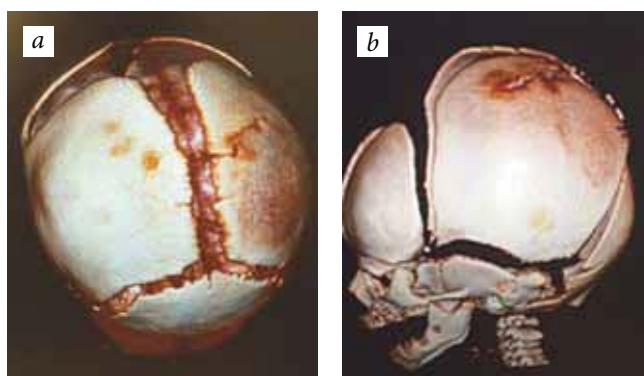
Spiral computed tomogram of the skull. Linear fracture with lacunar craniopathy. *a* — top view; *b* — side view
